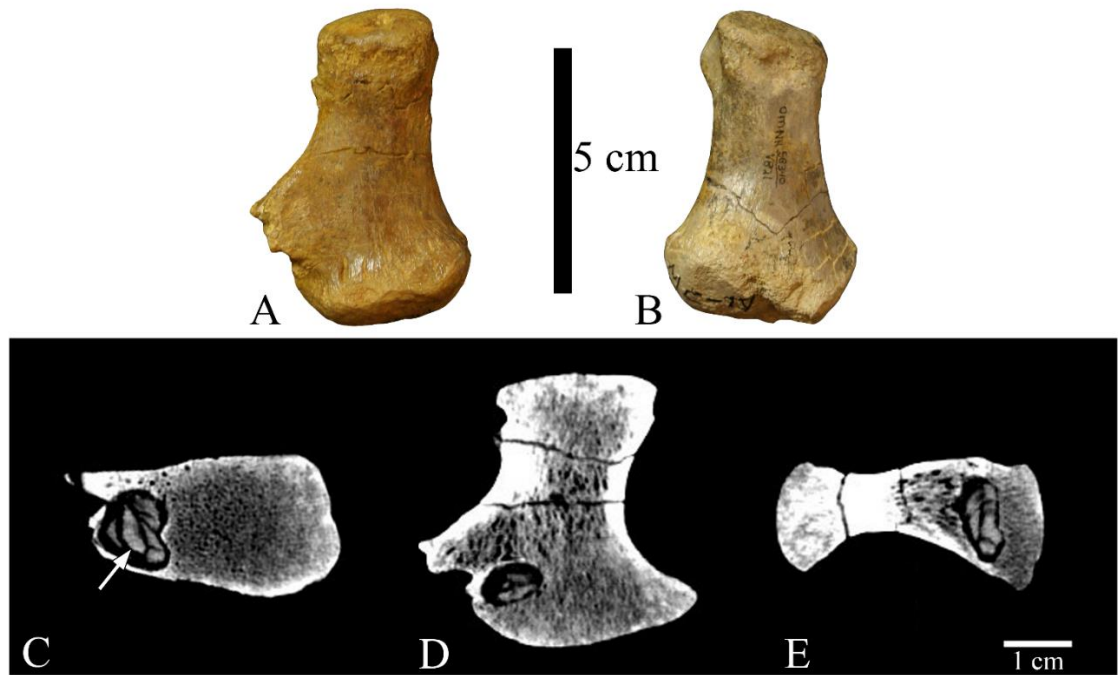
OMNH 58340 left and right metacarpal IV. A. Left metacarpal IV dorsal view B. Right metacarpal IV dorsal view. C-E. Computed tomography scans of left metacarpal IV showing the internal morphology consistent with a type of subacute pyogenic osteomyelitis called a Brodie abscess. C. Proximal view D. Dorsal view E. Lateral view. Arrow indicates the presence of an irregular sequestrum within the abscess consistent with a Brodie abscess in an early stage of its development.
